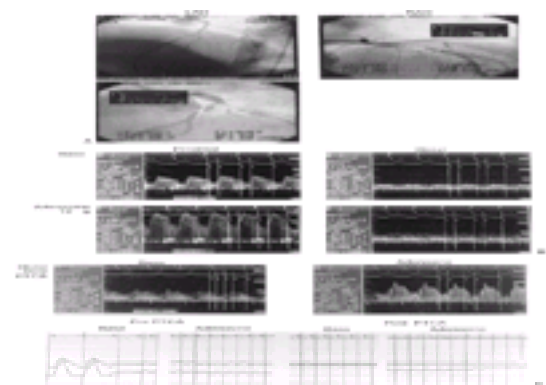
Angiogram of a left anterior descending (LAD) stenosis. (LAO, left anterior oblique projection; RAO, right anterior oblique projection.) Coronary angiography revealed a 60% diameter narrowing in the proximal left anterior descending coronary artery in this young man 6 days after an anterior myocardial infarction. In-laboratory assessment of the stenosis was performed before and after angioplasty. Basal and hyperemic flow velocity data were obtained 1 cm proximal to the stenosis. The Doppler guidewire was advanced across the stenosis. Distal (more than ten artery diameters or 2 cm) basal and hyperemic flow responses were obtained. Intracoronary adenosine (12 to 18 μ g) was administered through the guide catheter to evaluate poststenotic coronary reserve.
